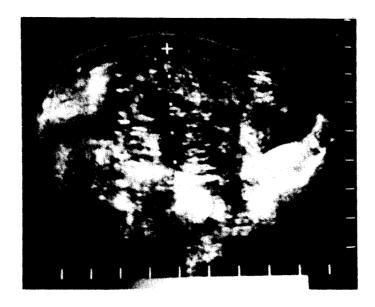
Ultrasonogram of mucinous cystadenocarcinoma.
